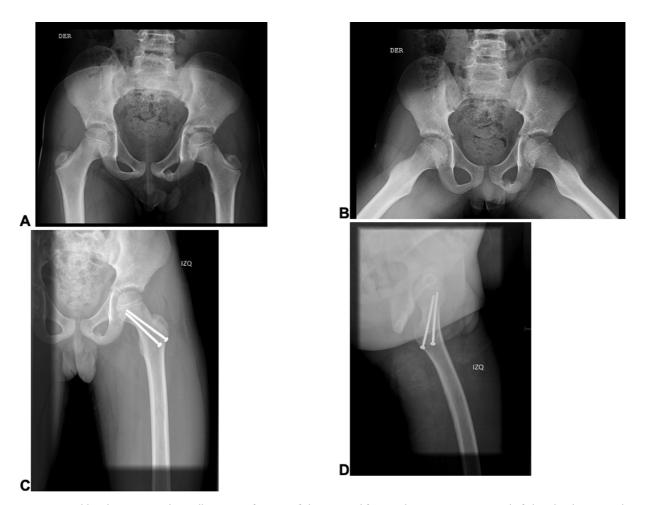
A 7-year-old male patient with a Delbet type-II fracture of the proximal femur. The treatment consisted of closed reduction and osteosynthesis with cannulated screws. (A,B) Preoperative radiographs showing a non-displaced fracture of the femoral neck. (C,D) Postoperative radiographs showing anatomical reduction and osteosynthesis with cannulated screws.
